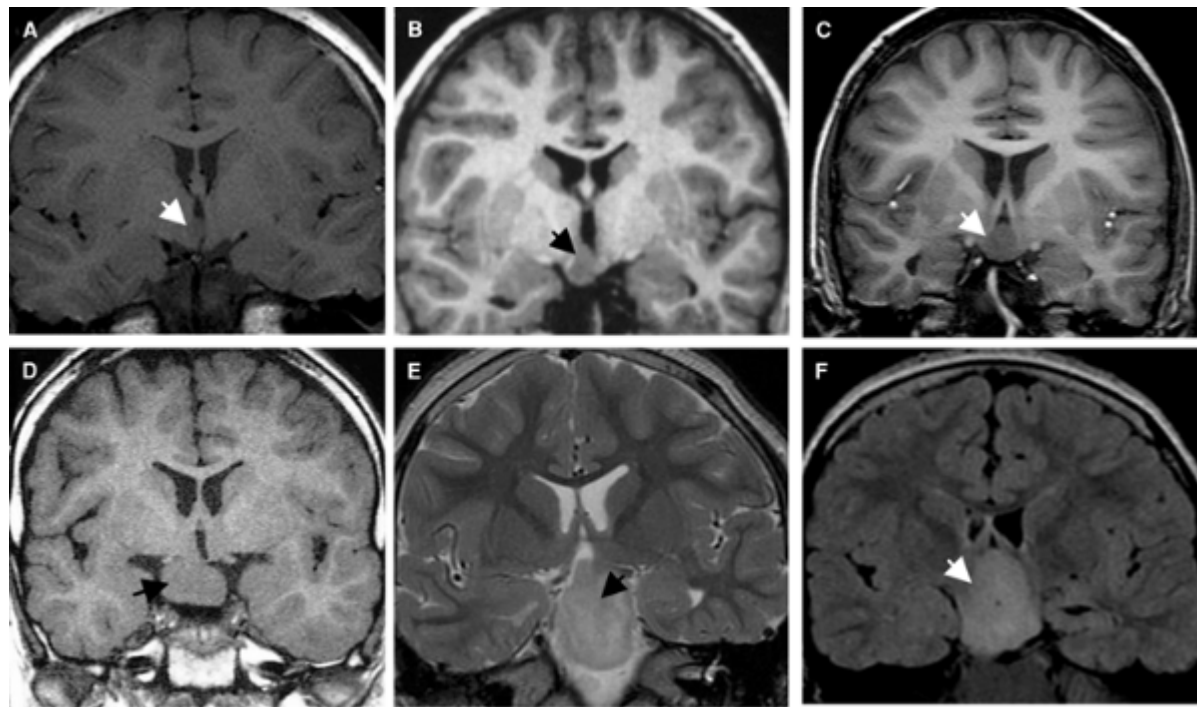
Coronal magnetic resonance images of six patients with gelastic seizures and hypothalamic hamartoma (HH) of different sizes and attachments. A, B: Small, unilateral, intraventricular HHs. C: A moderate size, bilateral, intraventricular HH. D, E: Large, unilateral HHs attached broadly to the ventricular wall and tuber cinereum. F: A large, bilateral, intraventricular HH, which distorts the hypothalamus and extends into the interpeduncular cistern.
